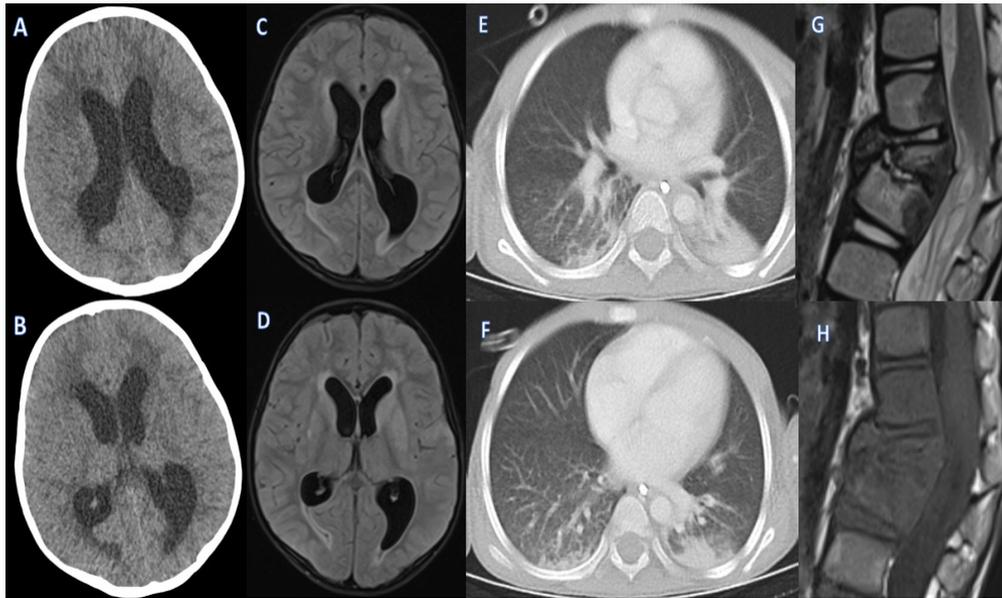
A,B Cranial CT: Hydrocefalic dilatations in the 3rd ventricle and lateral ventricles. C,D Cranial MRI: Hyperintense areas on the basal ganglions, temporal lobes and discrimination line of gray-white matter on the right frontal lobe, also in the FLAIR secans and diffusional series. Gyral type contrast enhancements in the bilateral cerebral hemispheres and basal cisternas. E,F Torax CT: atelectasis and consolidations on the parenchymal sites and superior segments of lower lobes of lungs. H,G: Lomber MRI : Paraspinal abscess which is started at the level of posterior sides of f L1, L2, L3 vertebras reaches by the transeverse processes.
